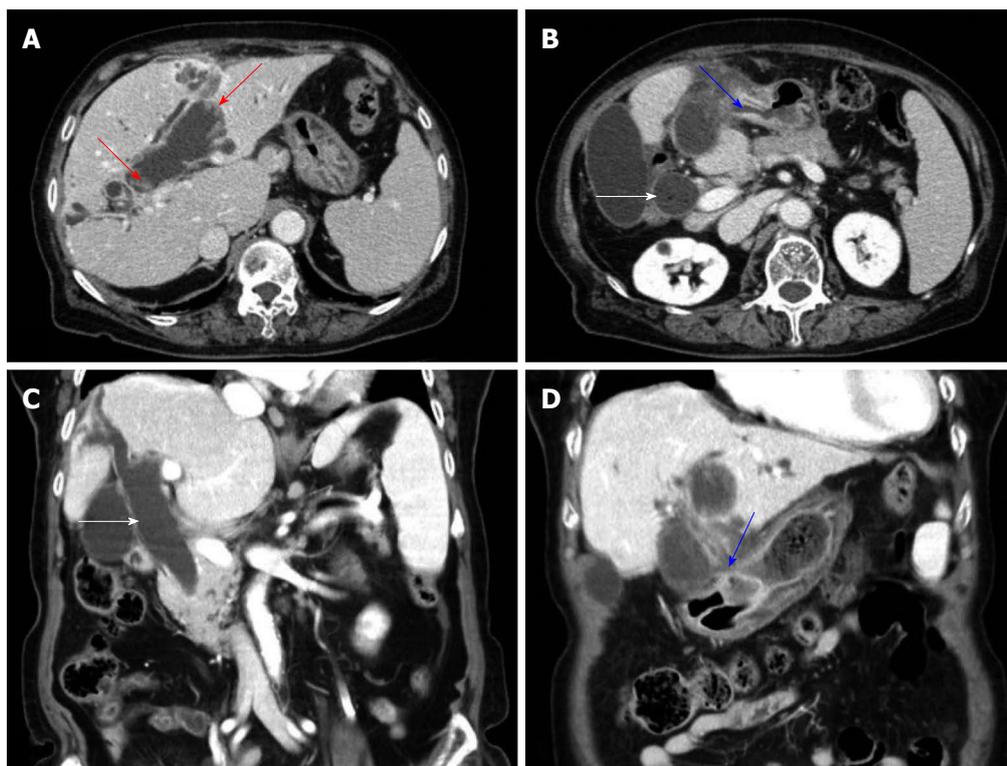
Computed tomography of the abdomen showed markedly dilated common bile duct (white arrows) and left intrahepatic duct with left intrahepatic duct penetrating into the antrum of stomach and fistula formation (blue arrows) and papillary projections along the dilated bile duct (red arrows) and no definite visible mass in the left intrahepatic duct (A-D).
